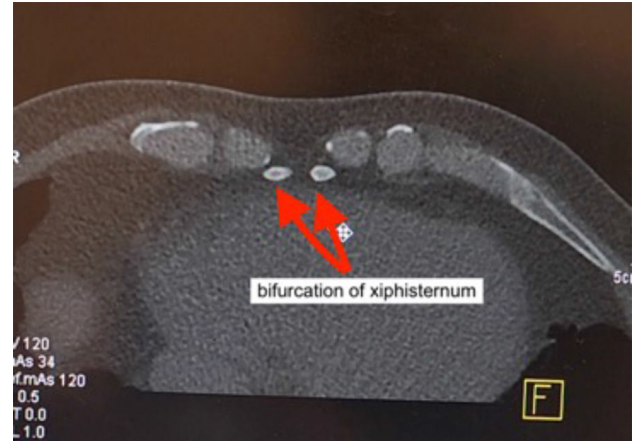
Pre-operative CT abdomen reveals bifurcation of the xiphisternum confirming the diagnosis of Bifid xiphisternum
